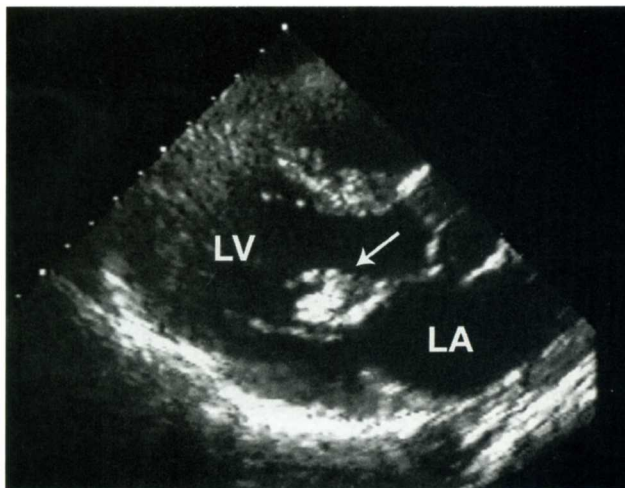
Endocarditis. Parasternal long-axis view with echogenic mobile vegetations on the mitral valve leaflets (arrow). LV = left ventricle, LA = left atrium. (Courtesy of Lori Sens and Lori Green, Gulfcoast Ultrasound)
